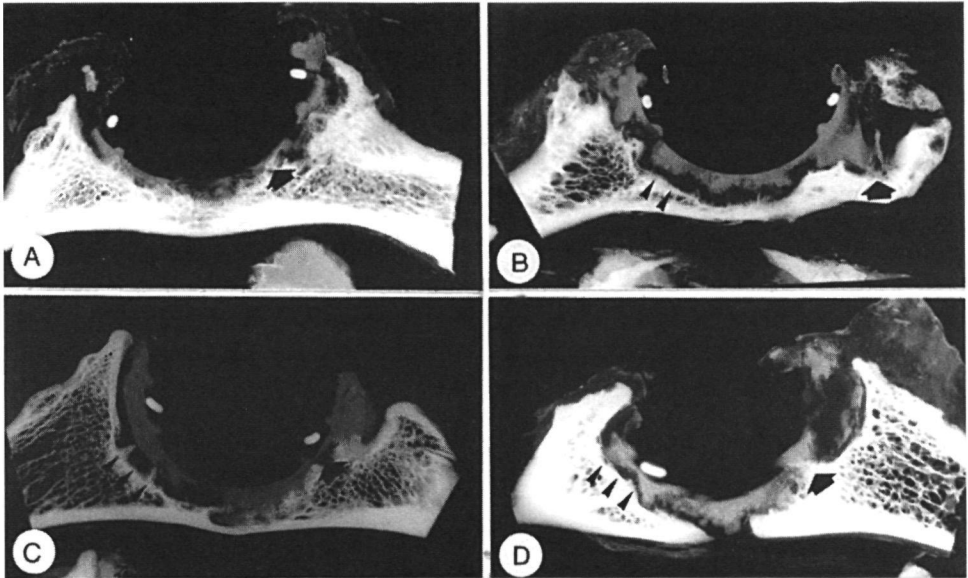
X-rays of thick sections after 24 weeks (A. and B.) and 48 weeks postoperatively (C. and D.). Note the areas of direct bone-cement contact (arrows) and interface formation (arrowheads). *x1.5.*
